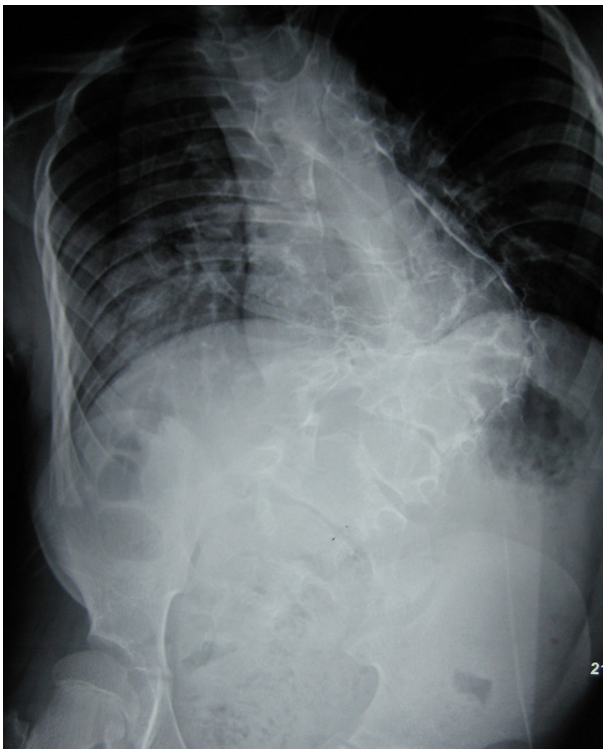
Anteroposterior spine radiograph showed congenital scoliosis anomalies
